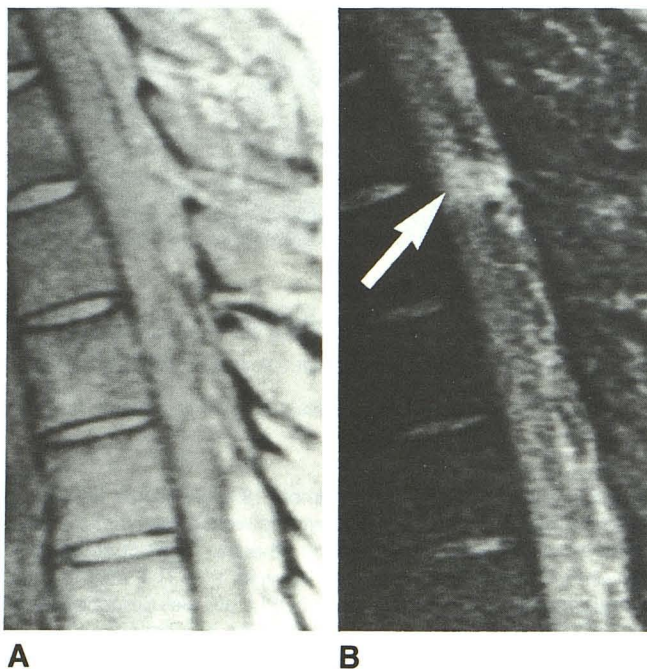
A and B, Sagittal SE 20/2000 (A) and 80/2000 (B) images obtained 2 weeks after injury show increased signal intensity in spinal cord (arrow) on T2-weighted image. Its bandlike appearance probably represents path of knife blade through the cord.
